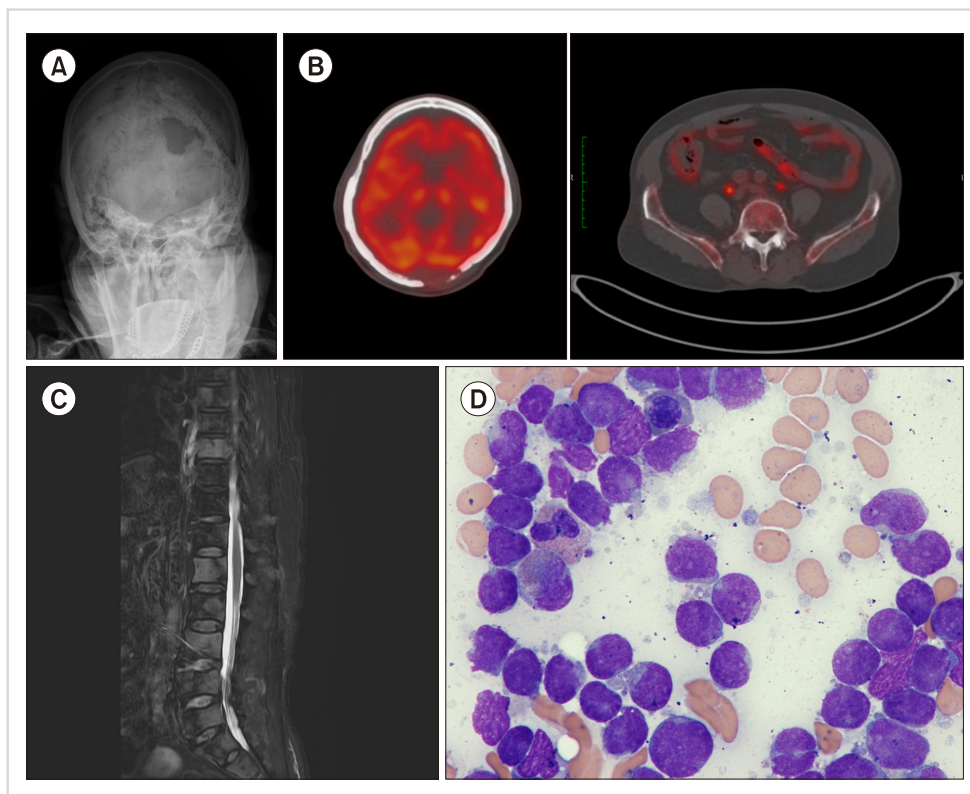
Simple radiography of the skull (A), positron emission tomography-computed tomography (B), and magnetic resonance imaging showing multiple osteolytic lesions in skull (C), vertebrae, rib, both pelvic bones, and a concurrent pathologic compression fracture in the thoracic vertebra; leukemic blasts observed in the bone marrow aspirate (D).
